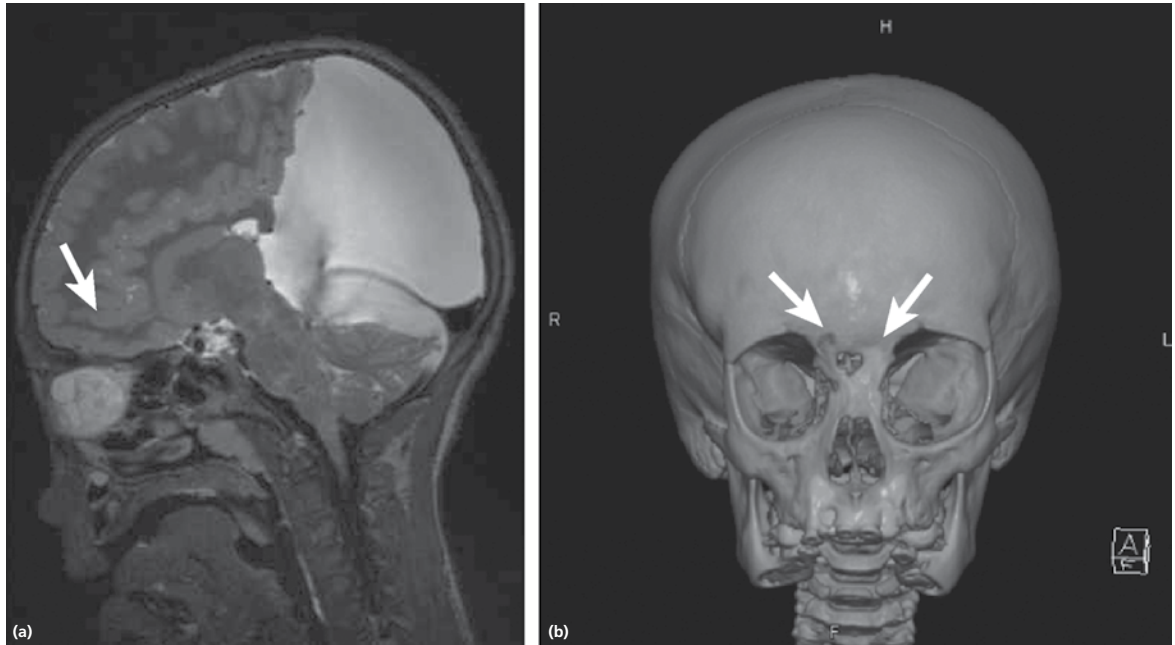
Encephalocele. An example of a midline herniation as seen on the (a) T2 weighted MRI scans (arrow) with cranium bifidum as seen on the (b) CT scan (arrow). This is an example of a neural tube defect.
